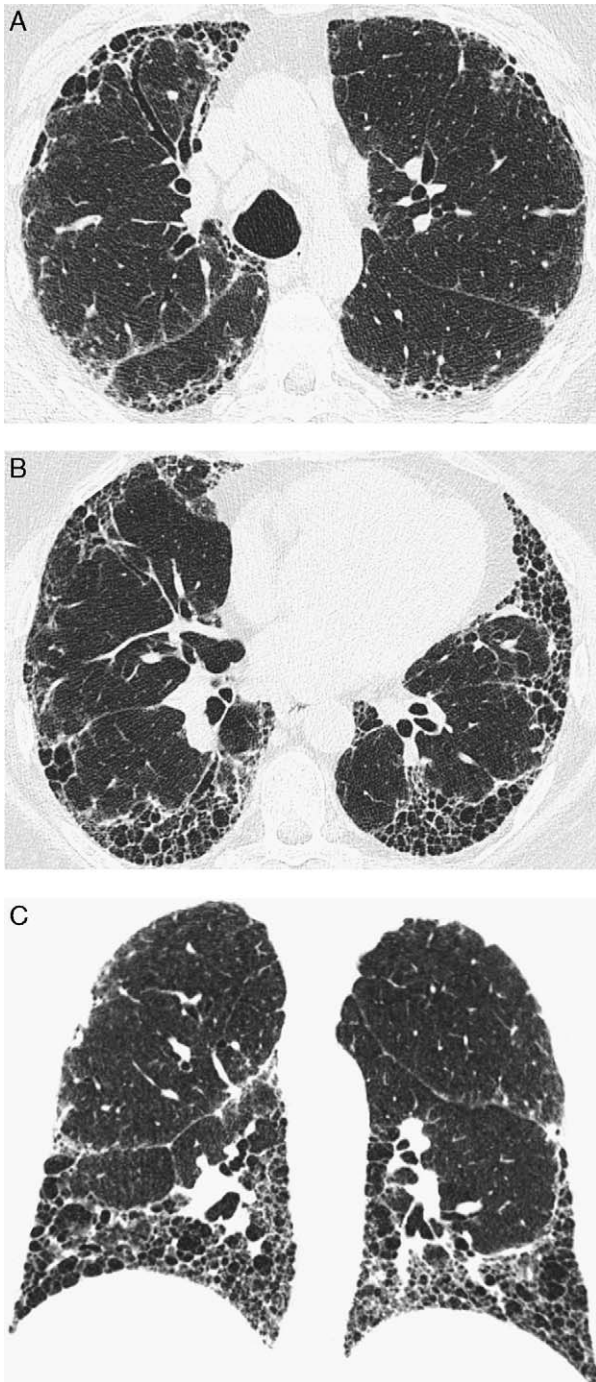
Typical HRCT findings of idiopathic pulmonary fibrosis in a 59-year-old man. A, HRCT image at the level of the upper lobes shows bilateral peripheral reticulation and honeycombing. B, HRCT image at the level of lung bases shows greater extension of peripheral honeycombing. C, Coronal reformation image shows mild peripheral reticulation in the upper lobes and extensive reticulation and honeycombing in the lower lung zones.
